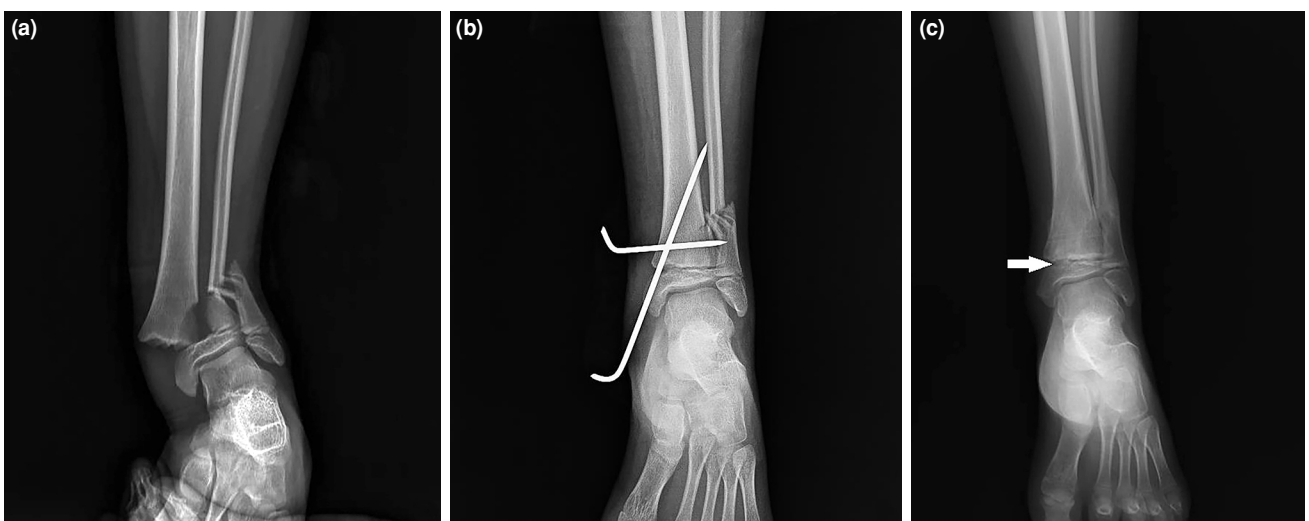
(a) Seven-year-old girl, Salter-Harris type 2 distal tibial epiphyseal fractures, pronation-eversion external rotation type fracture mechanism, accompanying fibula fracture. (b) Postoperative anteroposterior radiograph. (c) First year postoperatively, bone bar formation (arrowed area).
